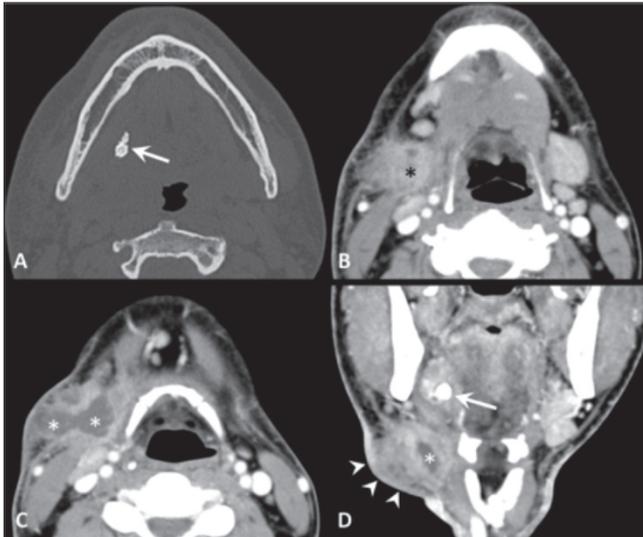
Obstructive sialadenitis complicated by extra-glandular abscess, contrast-enhanced CT. (A) The bone window image demonstrates a mineralised stone (arrow) within the right Wharton's duct. (B-D) The soft tissue window images show enlargement of the right submandibular gland (black asterisk), thickening of the submandibular fat tissue producing a "dirty fat" appearance. At the level of the neck swelling (arrowheads), CT demonstrates an abscess (white asterisks) in the submandibular space. The calculus is shown also the coronal plane (arrow).
